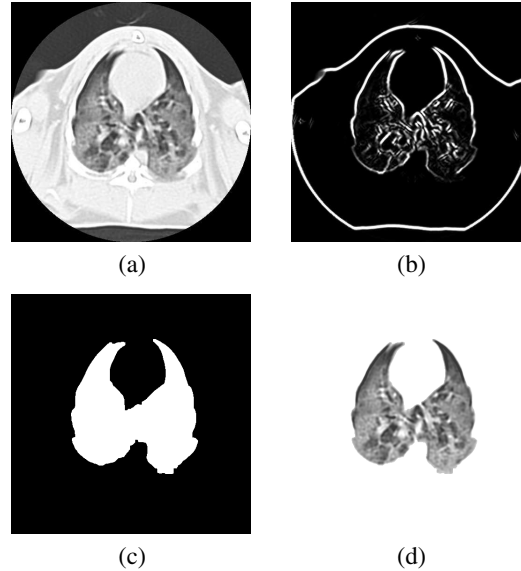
(a) An original CT thorax image. (b) 2D wavelet transformation; multiplication of third and fourth scales (c) obtained mask (d) Extracted lung.
